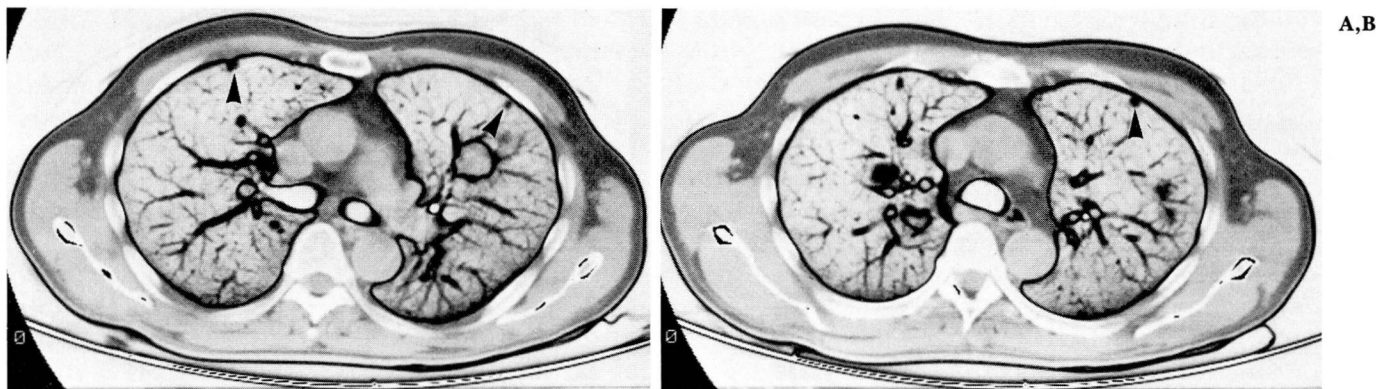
This patient underwent both conventional tomography and computed tomography of the chest to assess the extent of metastatic thoracic disease. Although the larger parenchymal nodules, identified in the left lung on A and in the right lung on B, were seen on conventional tomograms, the small pleural-based metastatic lesions in the anterior thorax (arrowheads) were not visualized on conventional linear tomography of the chest.
